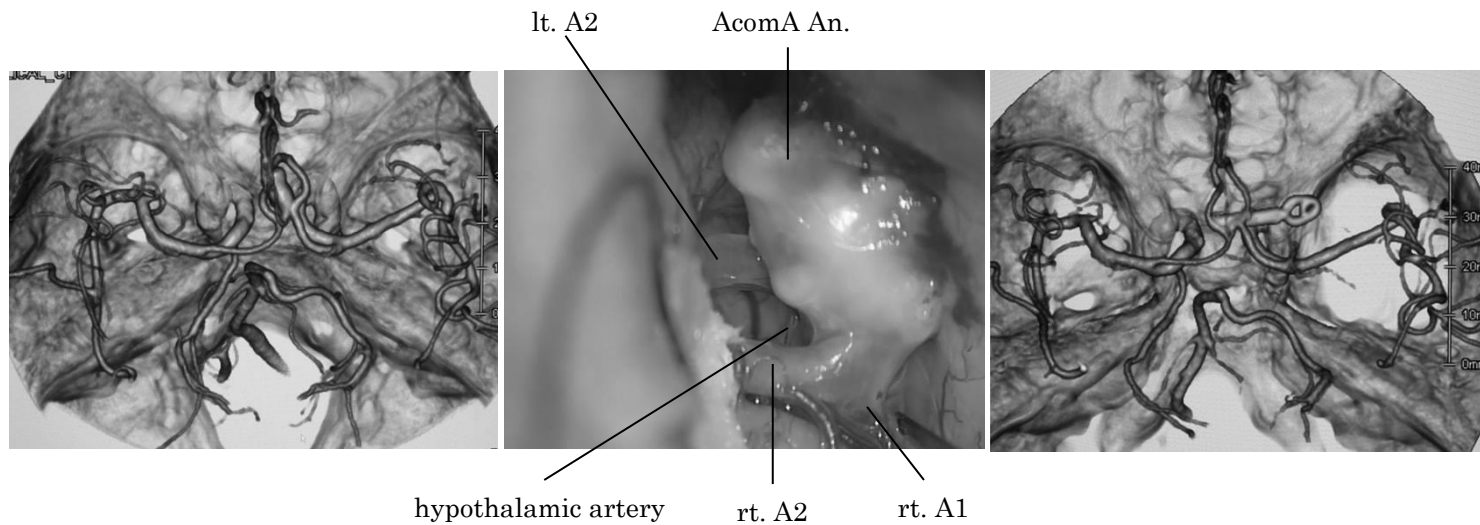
A 61-year-old woman with an anterior projection AcomA An (A). An AcomA complex was lateralized to right side. Rt. PA was performed. Intraoperative findings clearly revealed an AcomA complex, hypothalamic artery, and An.(B). A complete obliteration of the An. and preservation of each branches was confirmed by postoperative CTA (C).
